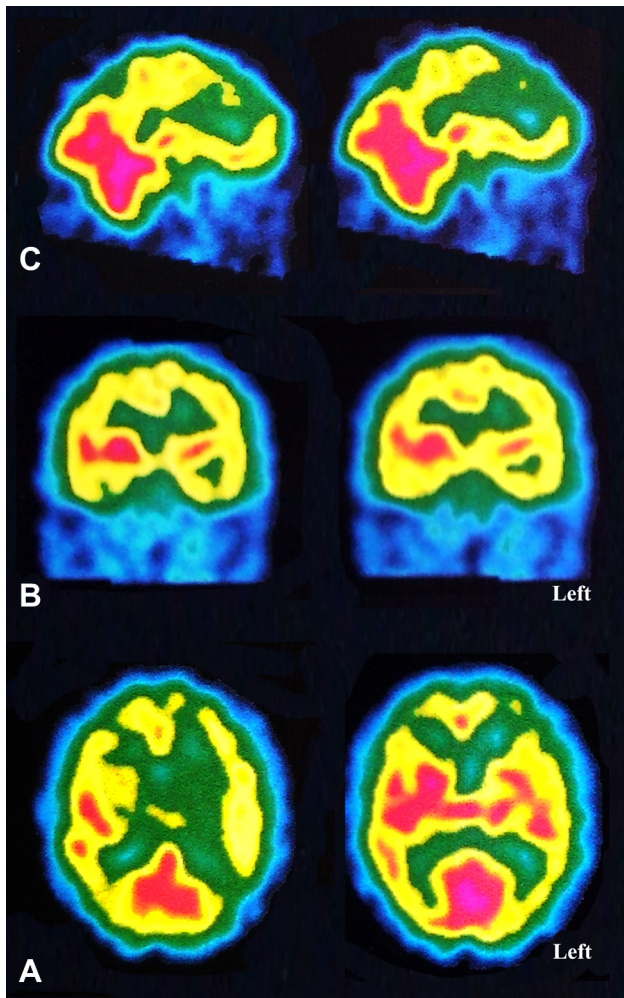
Sagittal (A), coronal (B) and frontal (C) brain slices of patient's (99m)-Tc-HMPAO SPECT scan. Functional images show diffuse decrease in perfusion (fronto-temporo-parietal regions bilaterally), more specifically in the left hemisphere within fronto-parietal and posterior temporal cortex.
